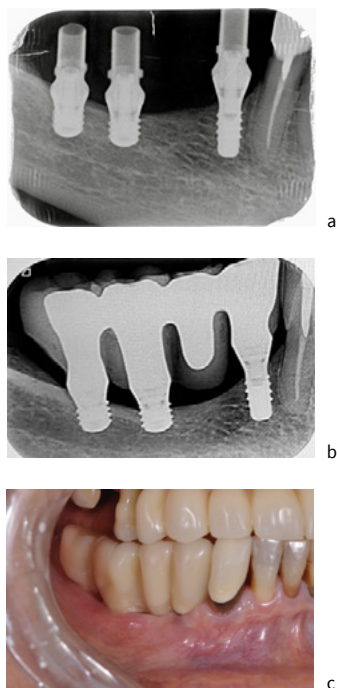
Posterior fixed partial denture supported by 2 very short and 1 small diameter implants which cannot tolerate saucerization as they could risk losing 50% of their bone support. a: Radiograph taken at the time of provisionalization. b: Radiograph taken 6 years after restoration showing excellent maintenance of crestal bone levels, despite unfavorable crown/implant ratio (>2.5). c: Clinical view showing elongated crowns to fill restorative space
